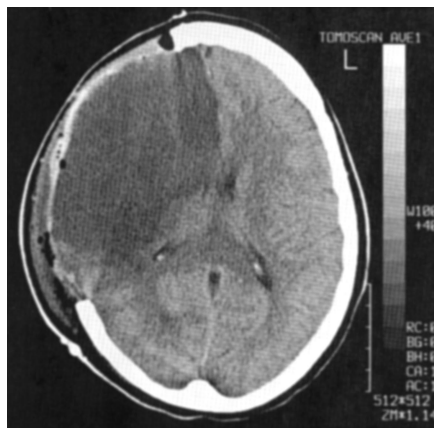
Computed tomographic scan of the same patient after decompressive surgery.
